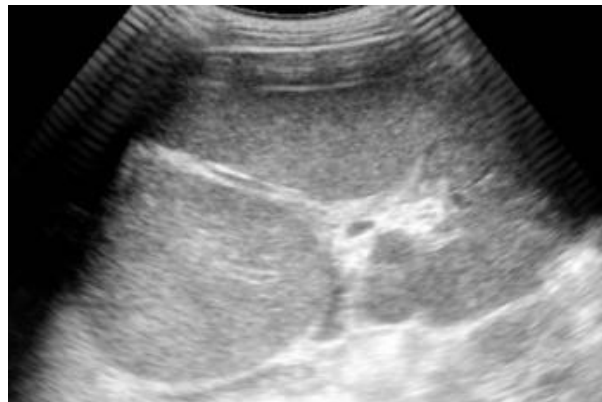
Renal Ultrasonography
